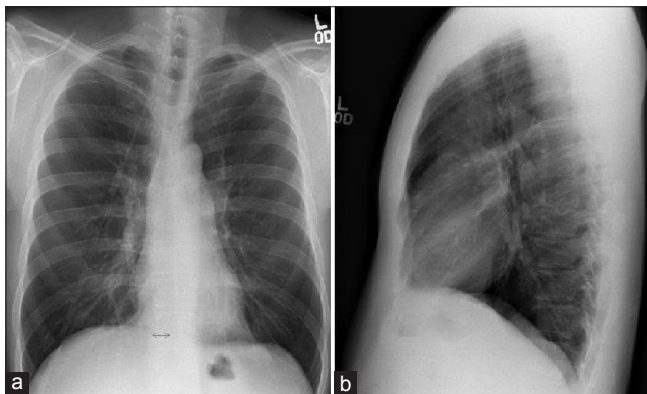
(a and b) Chest X-ray postero-anterior (PA) and lateral views revealing hyperinflation, horizontal ribs widened intercostal spaces and increased PA diameter suggestive of emphysema. Dated: April 2005
